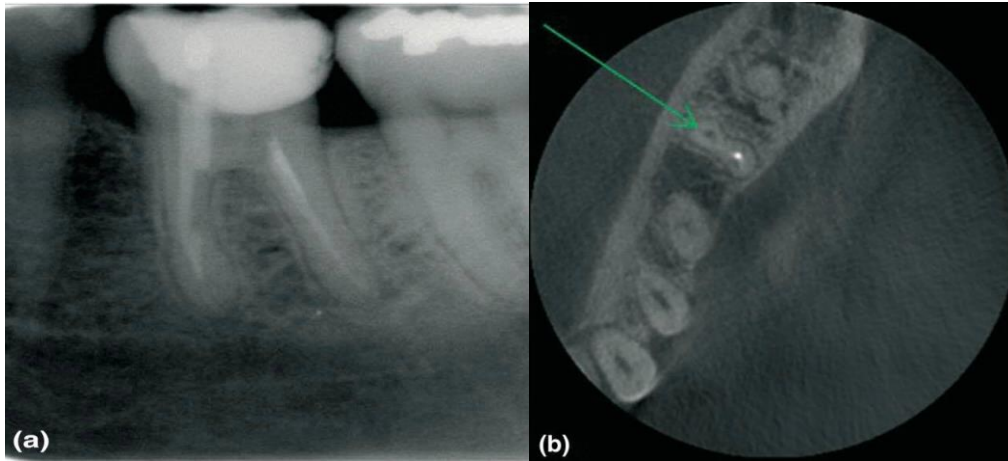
Periapical radiograph of a previously root canal treated tooth (36) with continued symptoms (a). The CBVT revealed an unfilled mesio-buccal canal indicated by the green arrow (b).
